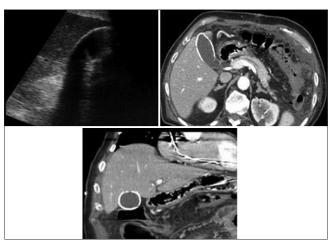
Porcelain gallbladder. Transverse right upper quadrant grayscale ultrasound shows strong posterior acoustic shadow, and axial and coronal contrast-enhanced computed tomography images of the upper abdomen each demonstrate thin intramural calcification of the gallbladder wall
